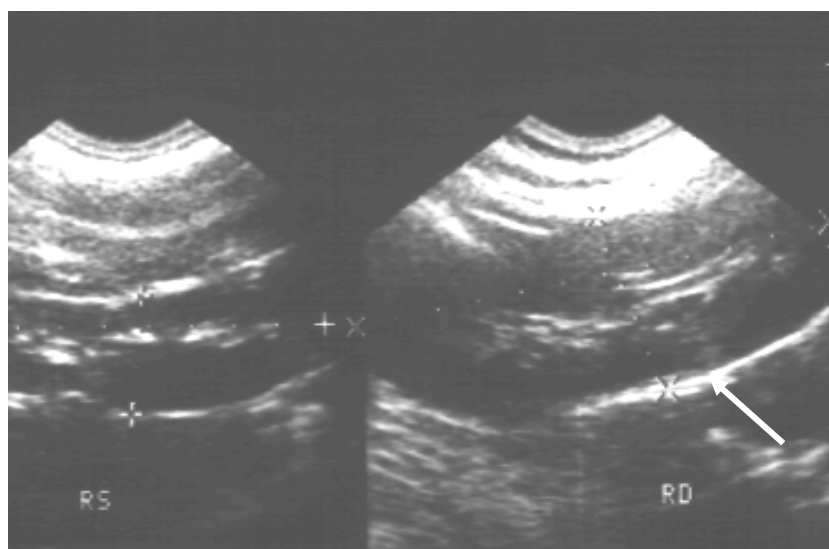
Acute pyelonephritis. Sonograms of kidneys. Enlarged parenchyma of a right kidney (26 mm) (arrow). Compare with left kidney. Acute pyelonephritis
